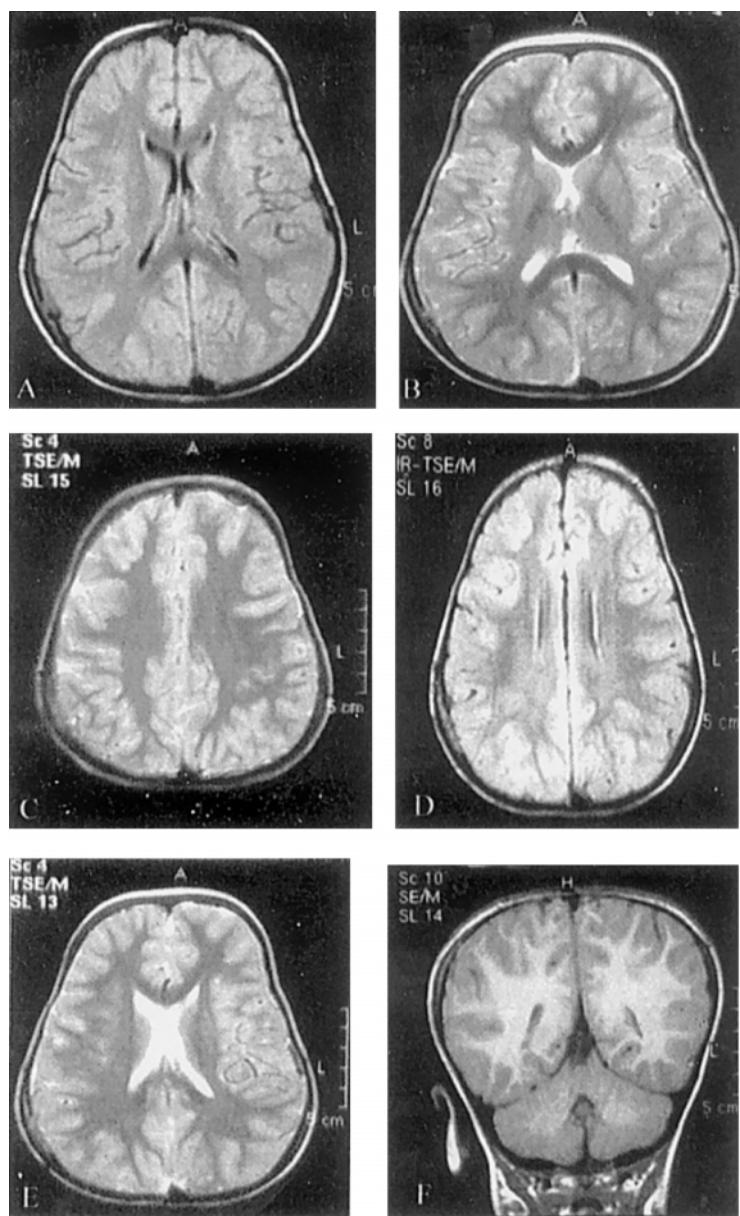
Axial MRI of the brain (T1 W, TR500/TE20) (A and D) and (T2W, TR1200, TE80) (B, C, and E) showing significant hypointense appearance (demyelination) of the white matter of the cerebrum, more manifested at the subcortical regions of the brain, with normal ventricular system. (F) Coronal T1W, TR500/TE20 demonstrating normal myelination of the white matter of one patient.
